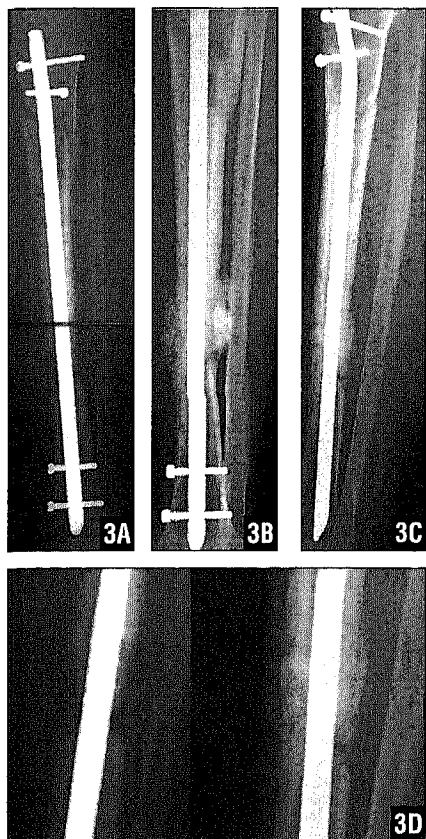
Radiographs of a 49-year-old patient with a compound double fracture of the tibia with loss of bone who was treated urgently with an external fixator and then with intramedullary nailing 1 month later. Given the persistent lack of bone and delayed consolidation in the distal fracture (A), platelet gel and hydroxyapatite were inserted into the site (B). The radiograph obtained after 6 months (C) and the comparison image (D) showed filling of the lost substance, the lack of areas of resorption, disappearance of the granular weave, and osteointegration.
